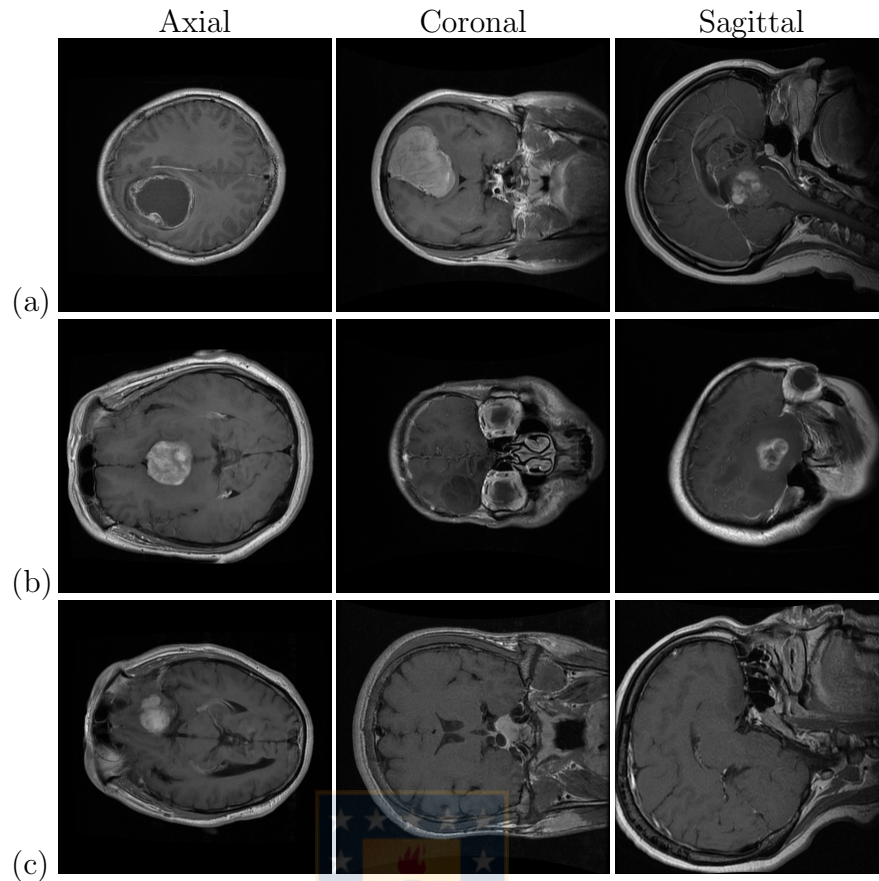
T1-weighted CE MRI dataset sample images for each anatomical plane (axial, coronal and sagittal) and tumor type.
